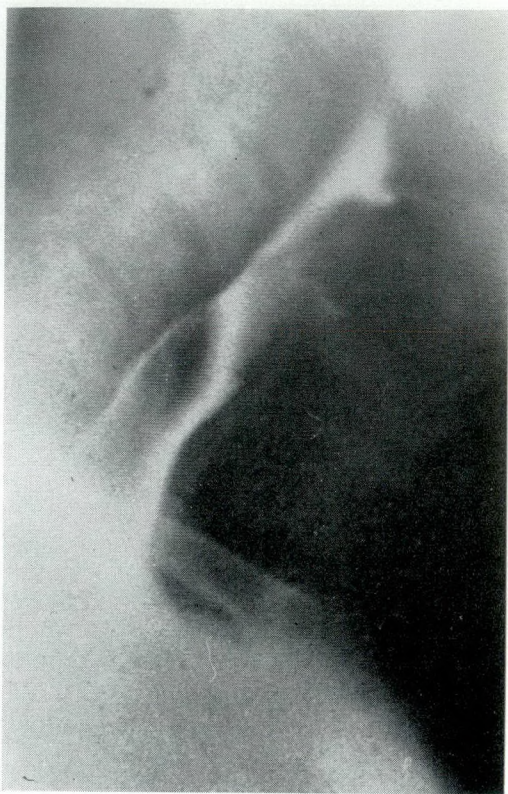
Case 2.—Postoperative radiograph showing no remnant of the diverticulum. This is a film taken during cinéradiographic examination. During this examination it was clearly shown that the bolus passed quickly through the cervical esophagus, and in this region the lumen was unusually large, demonstrating the incorporation of the diameter of the diverticulum into the total diameter of the postoperative esophagus.
